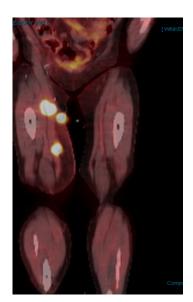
Pre-treatment staging PET/CT scan
